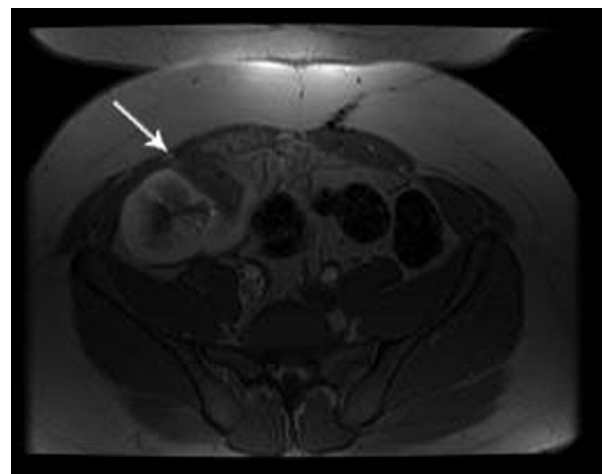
MRI scan at 9 months of follow-up of allograft renal cryolesion. Arrow demonstrates ablated region of tumor.
